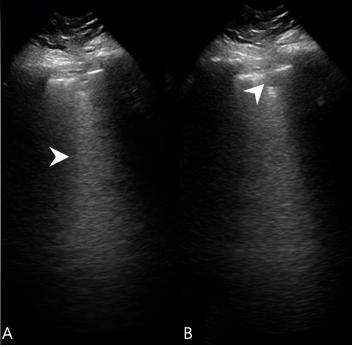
A) Lung ultrasound showing a B-line (arrowhead), and B) lung ultrasound showing a subpleural consolidation (arrowhead).
